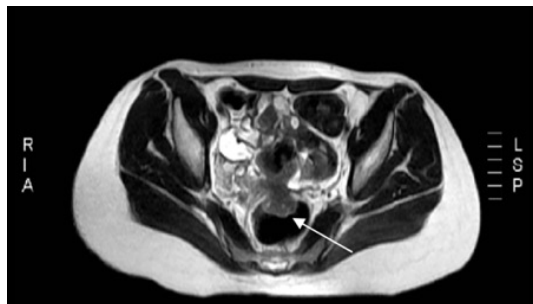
MRI showing the lesion on the anterior wall of recto sigmoid.
